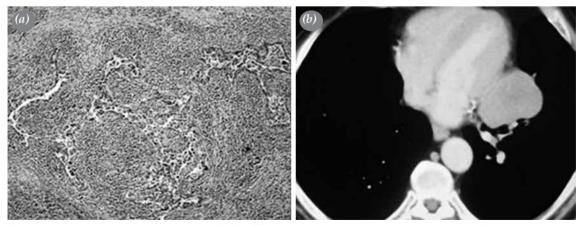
(a) Mucoepidermoid carcinoma of the lung (H-E x 200); (b) Computed tomography of the chest showing the solid lesion in the left lower lobe of the lung.
